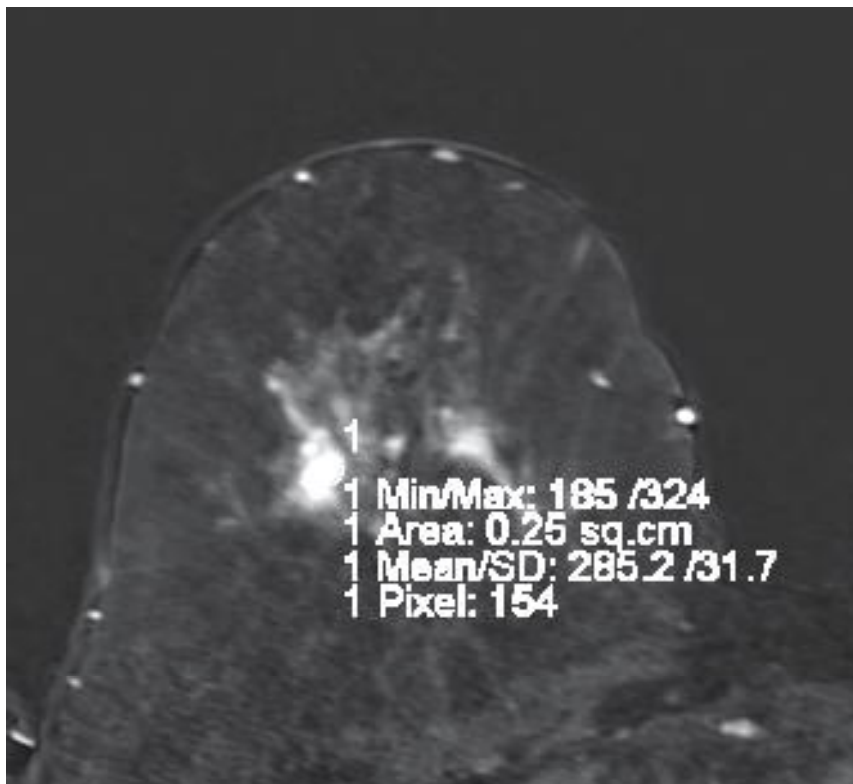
MRI identification and measurement of the suspected area.
